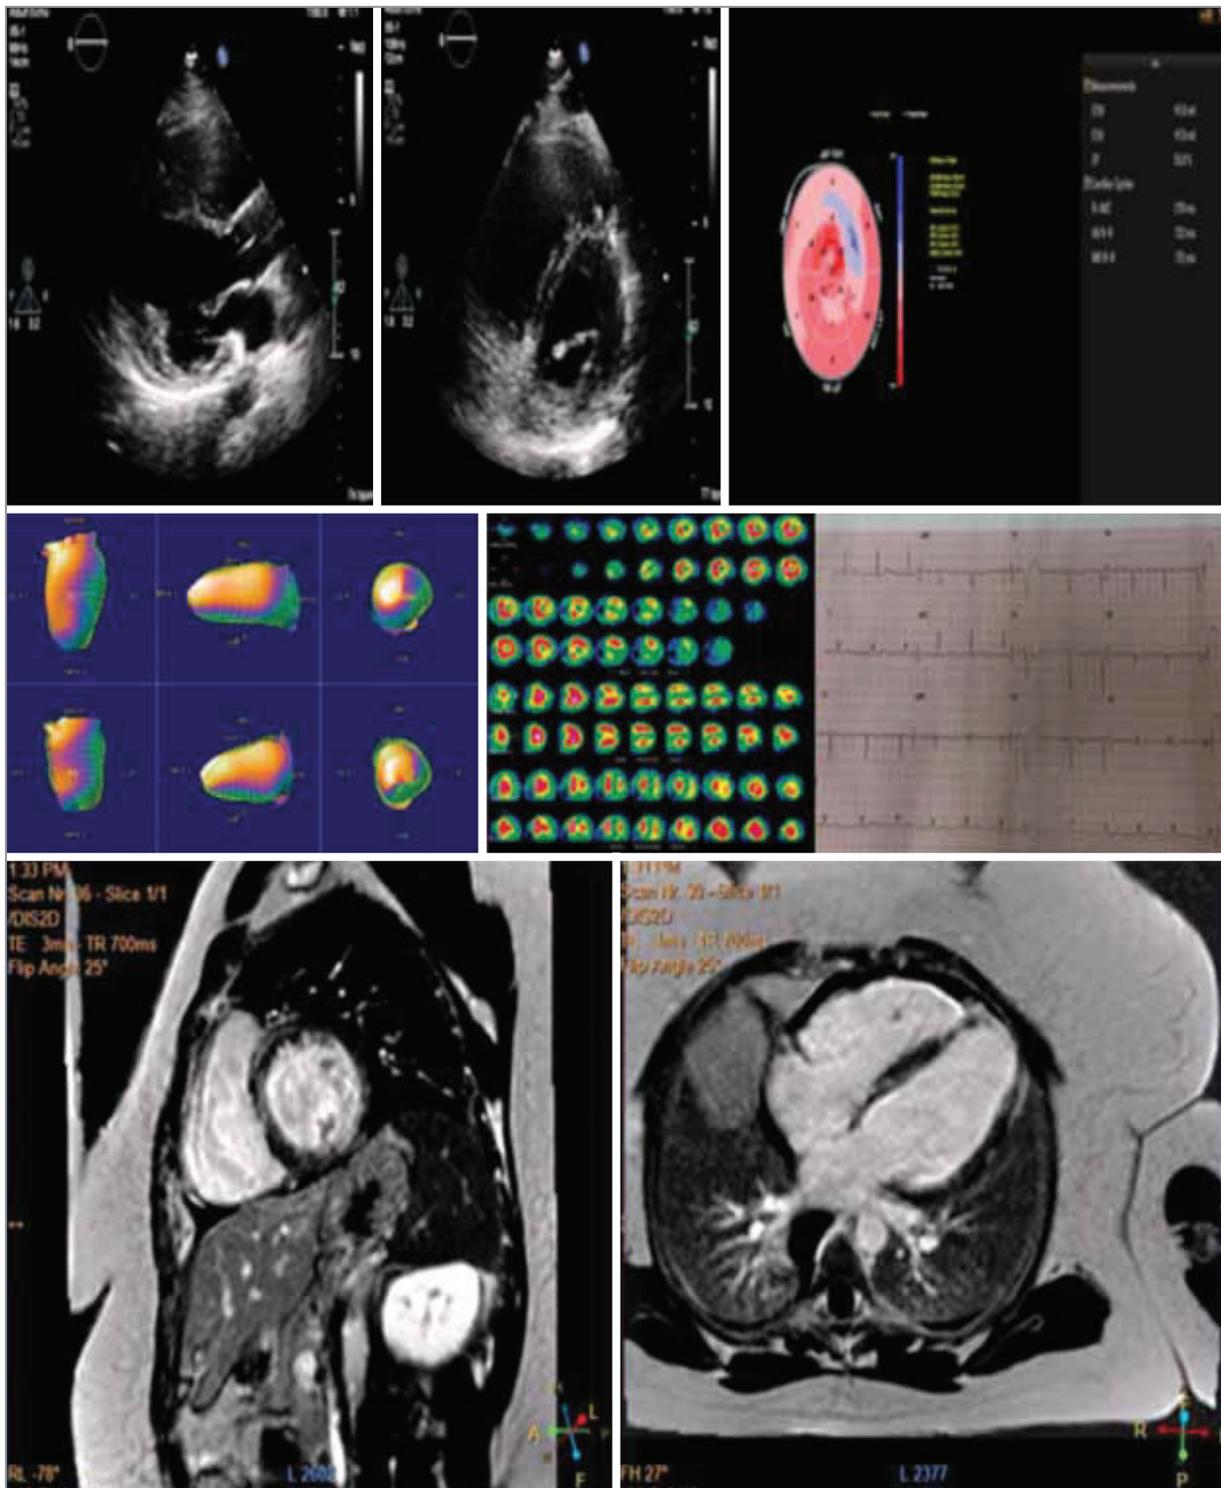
A case of systemic sclerosis complicated by an aneurysm and patchy fibrosis of the heart imaged with 2 dimensional echocardiography (top left and middle panel), strain imaging (top right panel), nuclear scan (top left and middle panel) and Magnetic Resonance Imaging (bottom panels).
